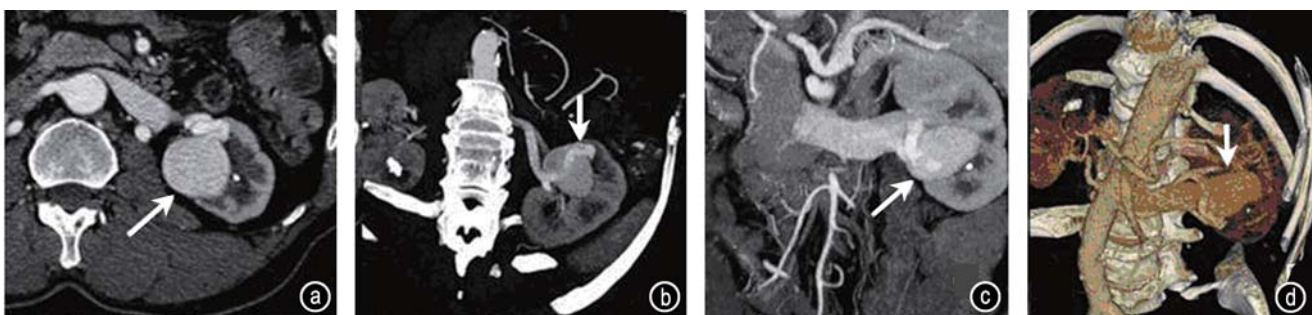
Left renal AVM (a-d). Gross hematuria without pain had emerged two years prior. Vascular malformation (long arrow) and feeding artery were observed in the cortical phase axial CT images (a). The lesion is visible as a round, bulky vascular malformation. Cortical phase enhancement of maximum intensity projection images (b and c) show AVM and feeding artery (arrow). 3D volume rendering images (d) show the feeding arterial and draining vein associated with RAVM, as well as the aneurismal dilatation (arrow). AVM, renal arteriovenous malformation; RAVM, renal arteriovenous malformation
